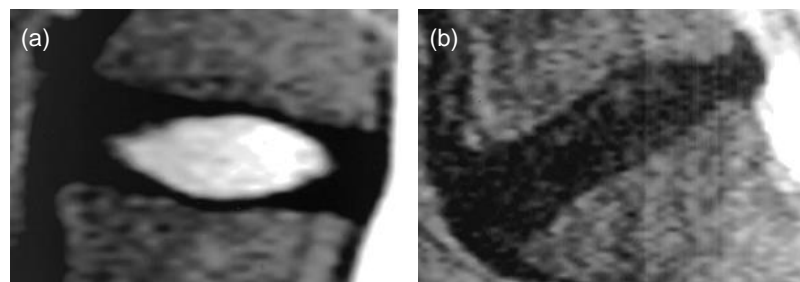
MR images from Pfirrmann *et al.* (2001) of discs *in vivo*, showing a healthy disc (a) and a grade IV degenerated disc (b). The signal intensity from the nucleus of the healthy disc is hyperintense. For the degenerated disc, the signal is much darker and the nucleus cannot be distinguished from the annulus.
